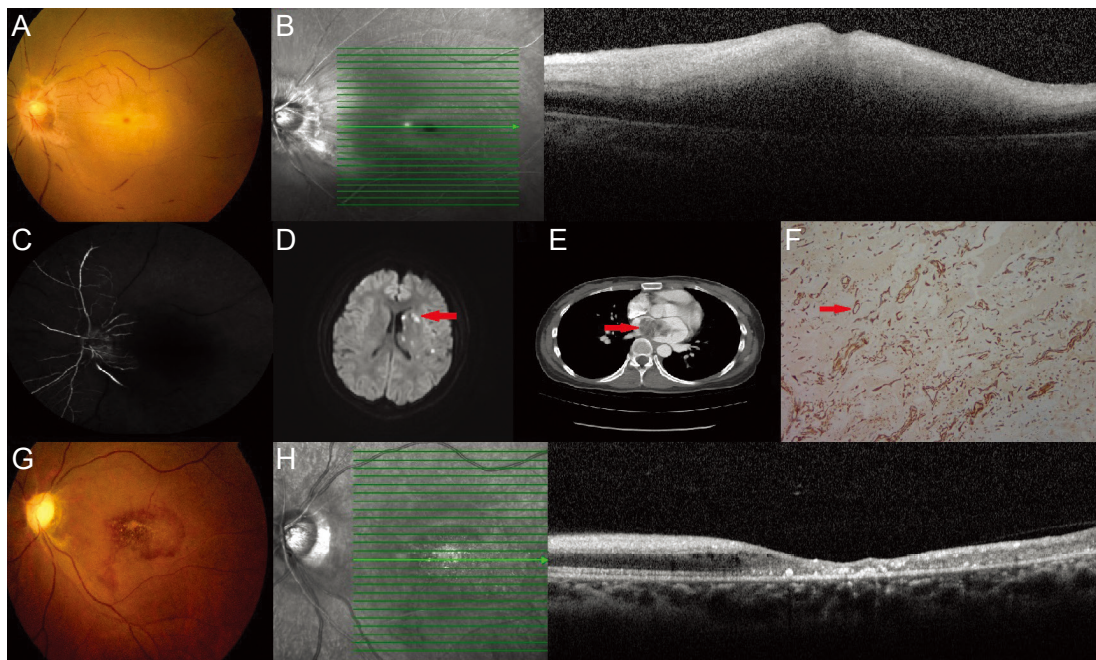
(A) Fundus photograph of the left eye shows retinal artery attenuation and a cherry-red spot. (B) Optical coherence tomography shows severe edema in the macula. (C) Fluorescein angiography of the left eye shows a delay in arterial filling at 5 minutes 37 seconds. (D) Brain diffusion-weighted magnetic resonance imaging shows acute multiple signal changes (red arrow) in the left middle cerebral artery territory. (E) Contrast-enhanced chest computed tomography scan shows a heterogeneous mass (red arrow) with fluid density in the left atrium. (F) Section from excised tissue shows CD31 positivity in the abundant blood vessels (red arrow), original magnification $\times 100$. (G,H) Follow-up fundus photograph and optical coherence tomography show atrophy of macula and optic disc.
